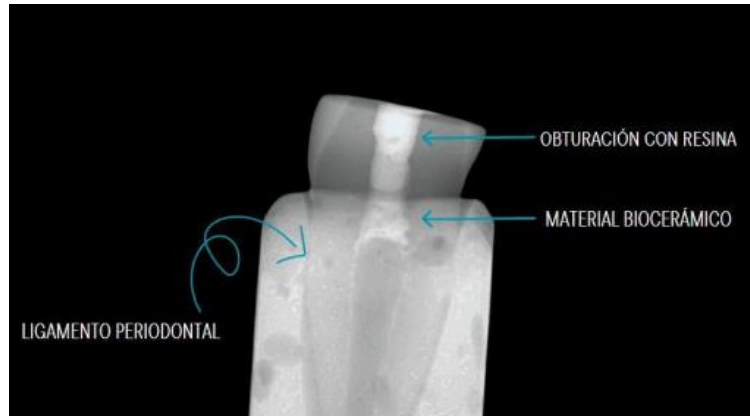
Radiographic verification of the placement of 3 mm of material.
